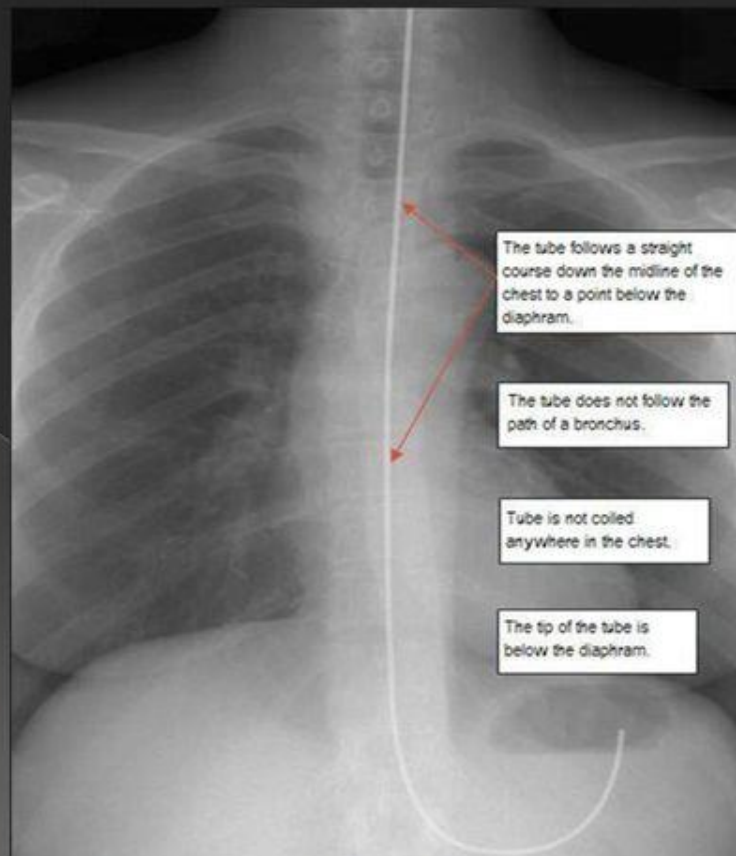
Chest Radiograph Representing Properly Placed Nasogastric Feeding Tube with Tip Visible
